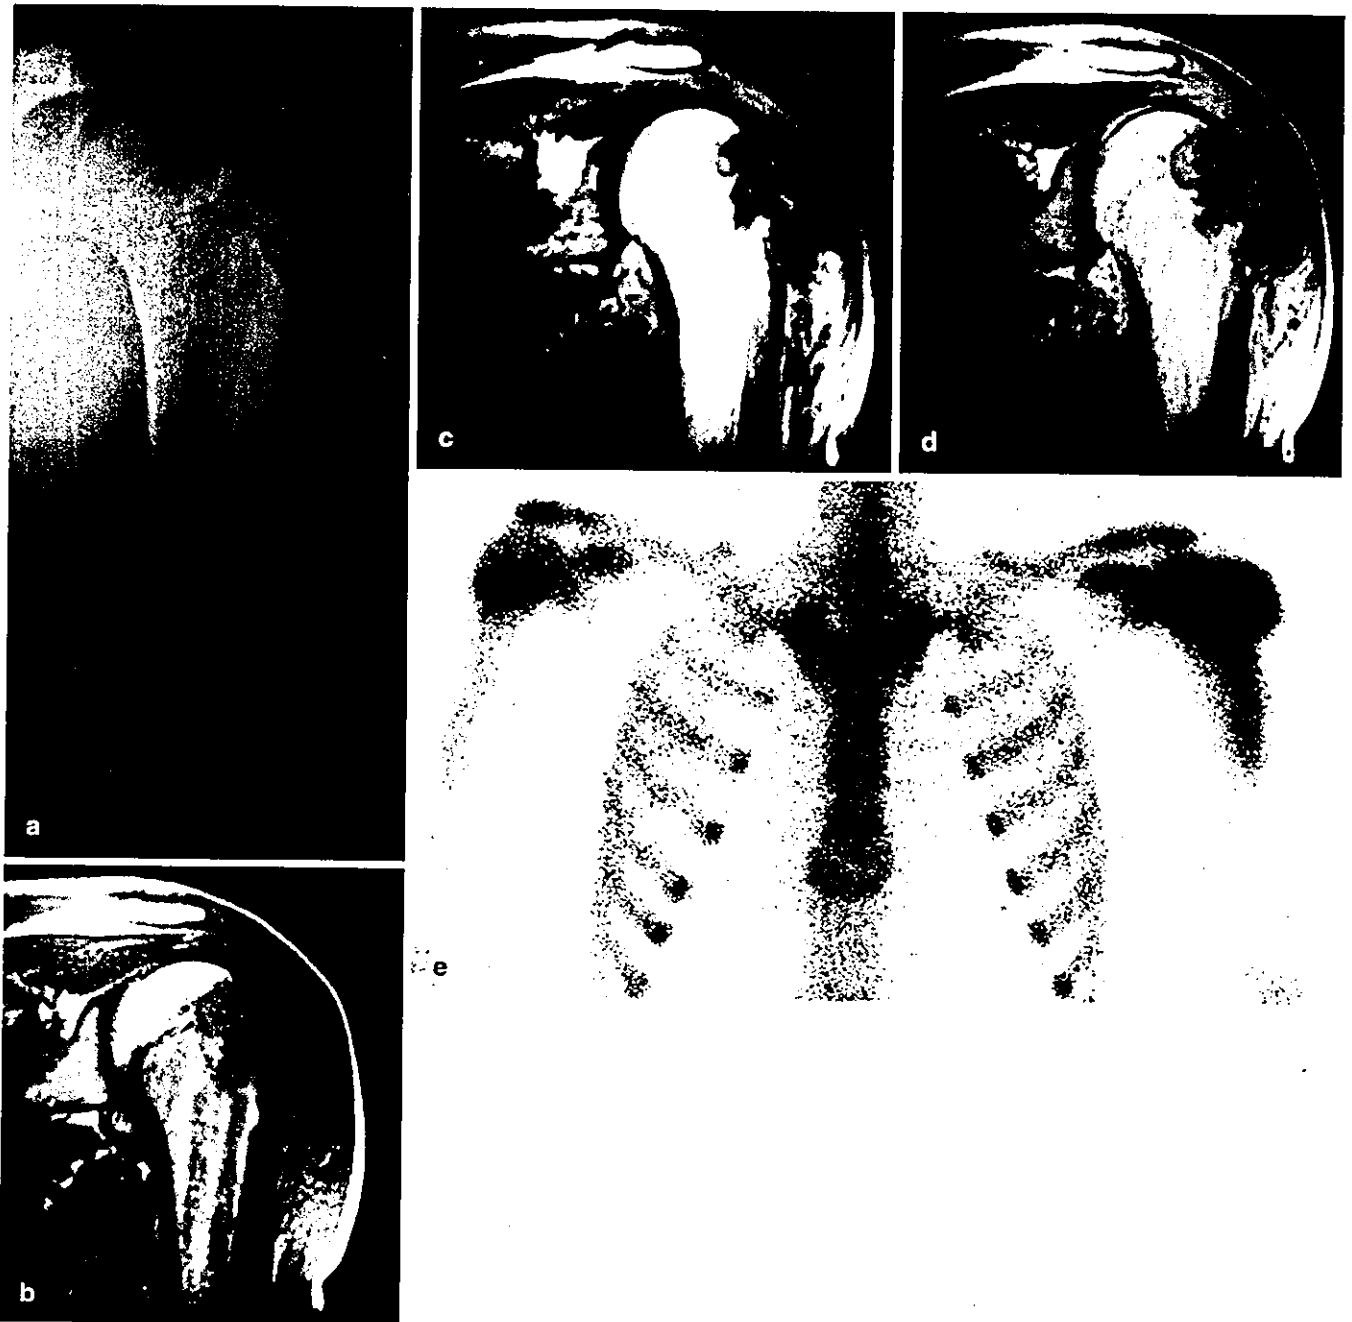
A A plain radiograph of the humerus shows a well-circumscribed calcified tumor of the epiphysis with conspicuous periosteal reaction of solid buttressing type along the diaphyseal shaft far from the tumor (case no. 8). B Coronal T1-weighted magnetic resonance (MR) image [repetition time (TR)/echo time (TE): 450/25] reveals a protruding tumor showing intermediate to low signal intensity. Bone-marrow edema is also identified as a longitudinal area of low signal intensity descending into the diaphyseal shaft. C Coronal T2-weighted MR image (TR/TE: 3000/
